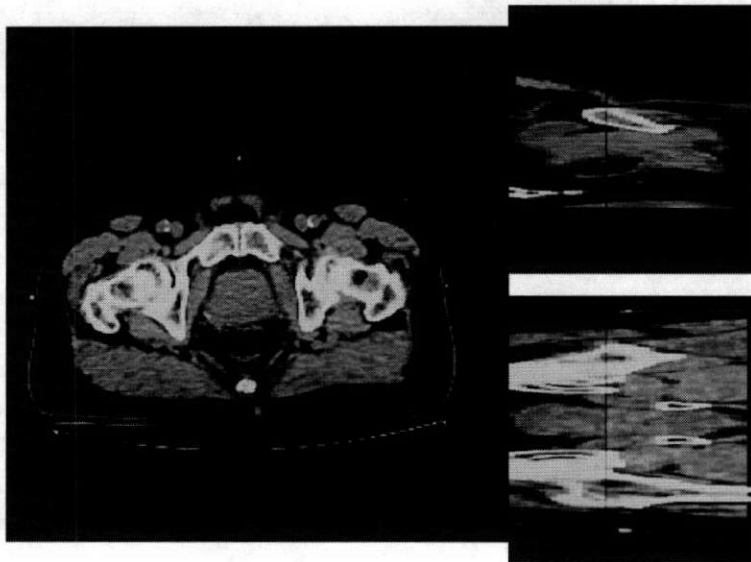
Overlapped orthogonal view of the CT images of the same prostate patient acquired during different days. The red component is the planning CT image, which is used as the reference image. The green component is the CT image acquired during the treatment day, which is used as the test image.
